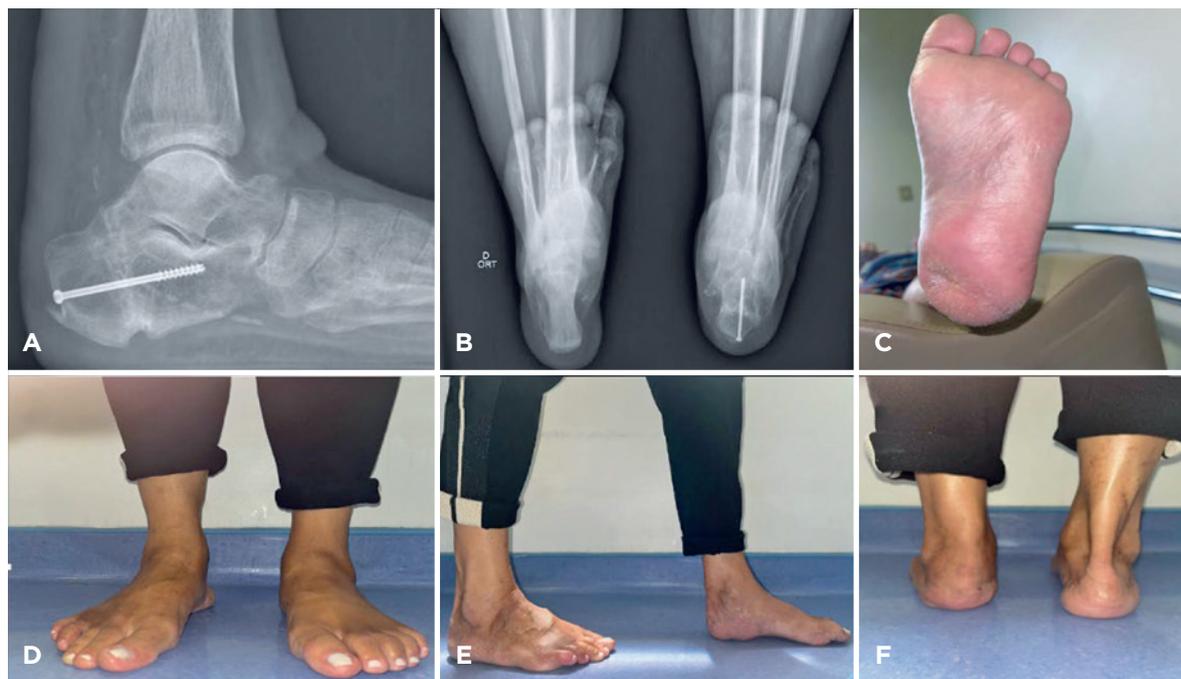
(A) Profile calcaneal radiography after 12 months (B) Bilateral Saltzman radiography after 18 months. (C) Healed wound. (D, E, and F) Clinical photos of the patient's foot, performing weight-bearing.
